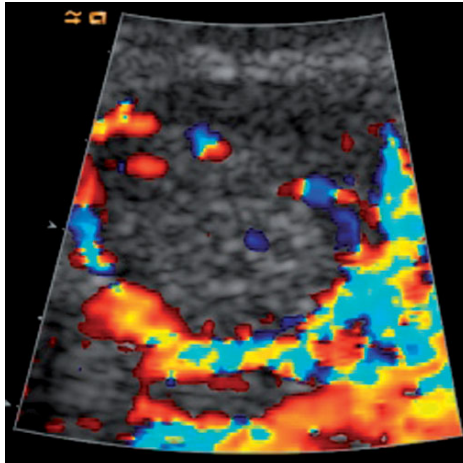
Color Doppler. Renal cell carcinoma. The basket-like appearance of the vessels delimiting the lesion make its identification easier
